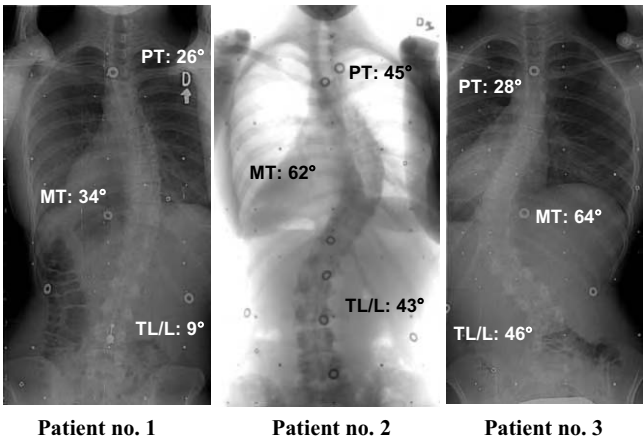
Preoperative posteroanterior radiographs of the three patients
